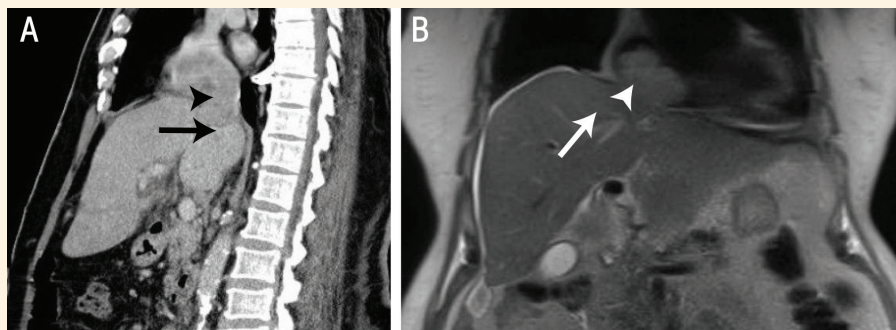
A: Computed tomography scan of the abdomen and chest of an 82-year-old man in the sagittal view showing a hepatocellular carcinoma (HCC) migrating through the hepatic veins and inferior *vena cava* to the right atrium (arrow), with a tumour *thrombus* located in the right atrium (arrowhead). B: Magnetic resonance imaging of the chest and abdomen in the coronal view showing the HCC migrating to the right atrium (arrow) and the tumour *thrombus* in the right atrium (arrowhead).
